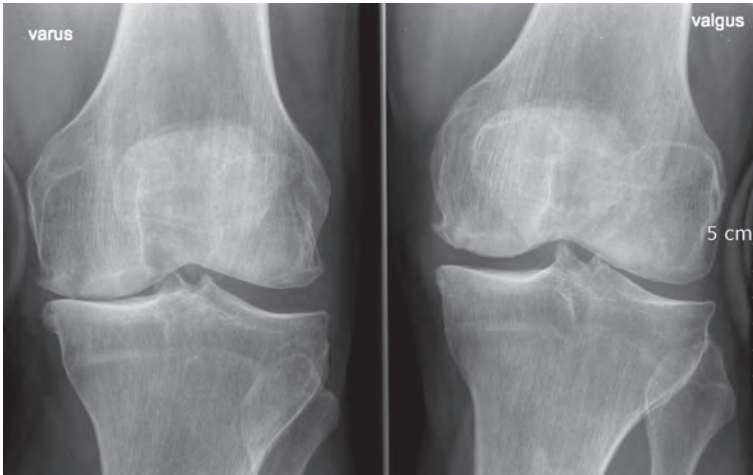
Varus and valgus stress x-rays showing the absence of lateral laxity and the reducibility of the medial joint space.
